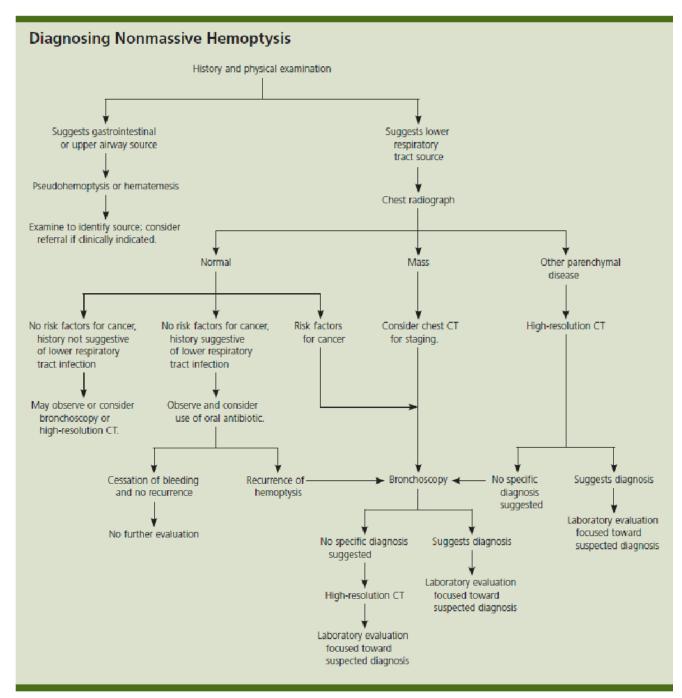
Algorithm for diagnosing nonmassive hemoptysis. (CT = computed tomography.)
